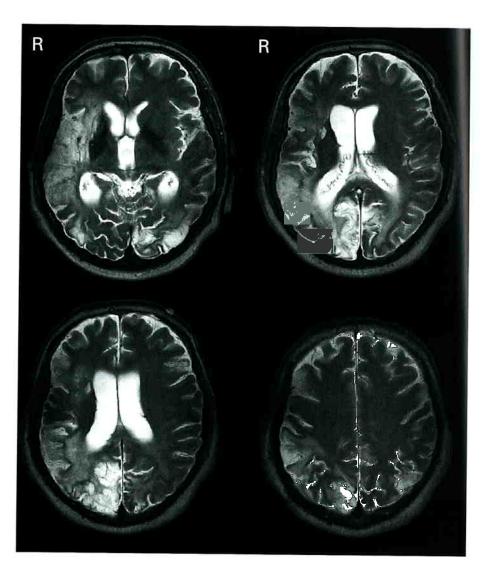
MRI (December 2002; T₂-weighted axial slices at the levels of the basal ganglia, the lateral ventricles and the centrum semiovale), documenting a severe worsening of the neuroradiological findings. In comparison to CCT in July 2000 (see text), an additional extensive infarction in the territory of the right MCA is depicted.
